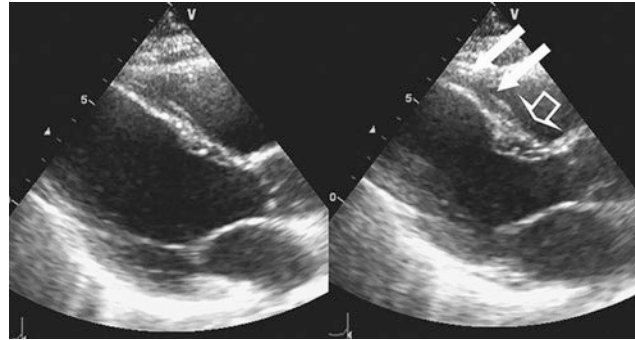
Echocardiography shows a typical wall motion abnormality in the left anterior descending artery perfusion territory due to an anterior myocardial infarction. *Left*, diastole; *right*, systole. The *long arrows*
